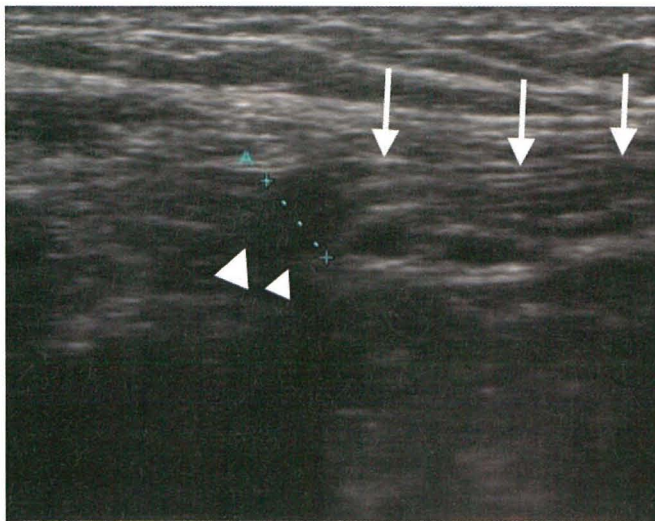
Ultrasound scan parallel to the course of the inguinal canal, showing the internal inguinal ring (arrowheads) and the inguinal canal (arrows) with its contents.
